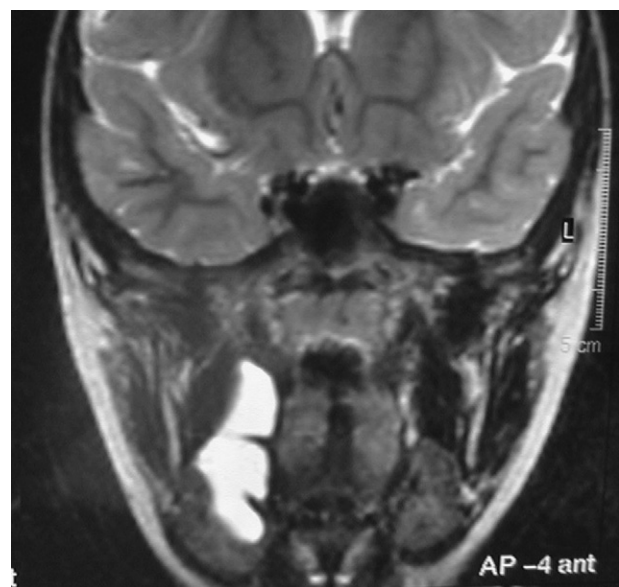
Case no. 8 MRI coronal view of the right ranula.
